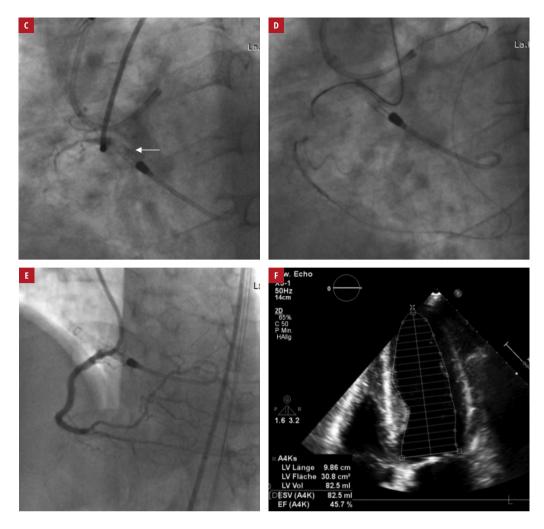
Intra- and postprocedural coronary angiography (C–E) and echocardiography (F): C – the position of the Impella 2.5 device at the aortic valve line (arrow); D – recanalization with the reverse controlled antegrade and retrograde tracking technique; E – the result of the procedure; F – predischarge echocardiography showing increased left ventricular ejection fraction of up to 45%
